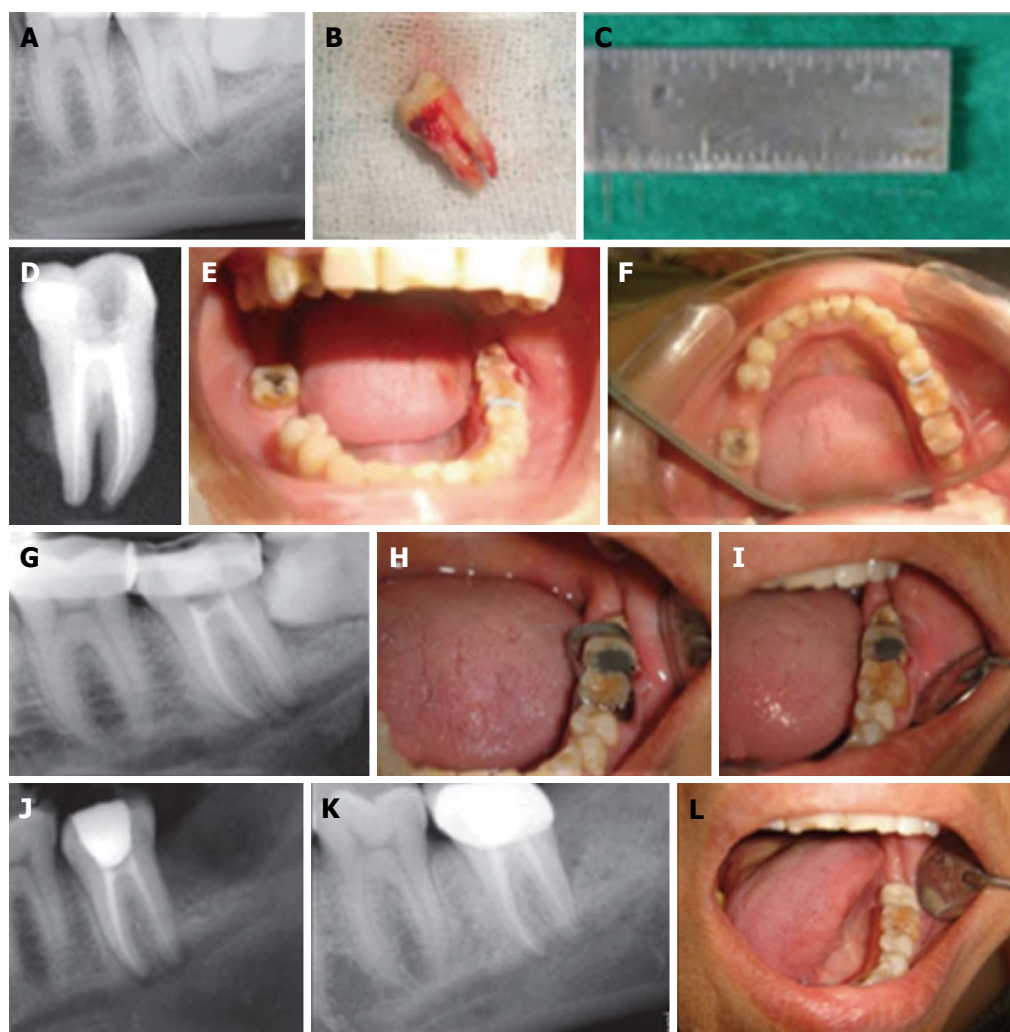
A separated hand instrument in a second molar was retrieved from the mesiobuccal root, which was close to the mandibular canal, using tooth replantation. A: Broken instrument near to the mandibular canal; B: After extraction; C: Measured broken instrument of 7 mm; D: After obturation; E: After separators were placed; F: Extra coronal splinting with orthodontic wires were prepared; G: Post operative Radiograph; H and I: Four weeks after Band removal; J: Three months follow-up Radiograph; K: One year follow-up radiograph; L: One year clinical radiograph.
